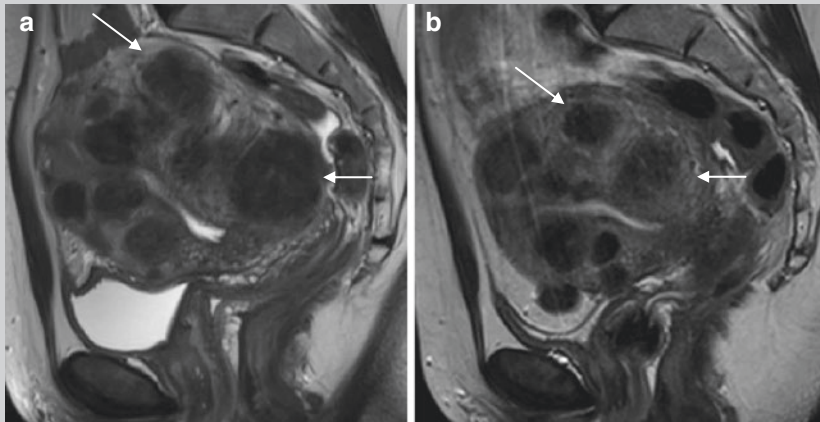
(a) Pre-procedure MRI was performed showing an enlarged uterus containing multiple T2-hypointense fibroids (*arrows*). These were suitable for UFE and the patient returned for treatment 2 weeks after her MRI. (b) Follow-up MRI 6 months after embolisation showing decrease in size of multiple fibroids (*arrows*)
